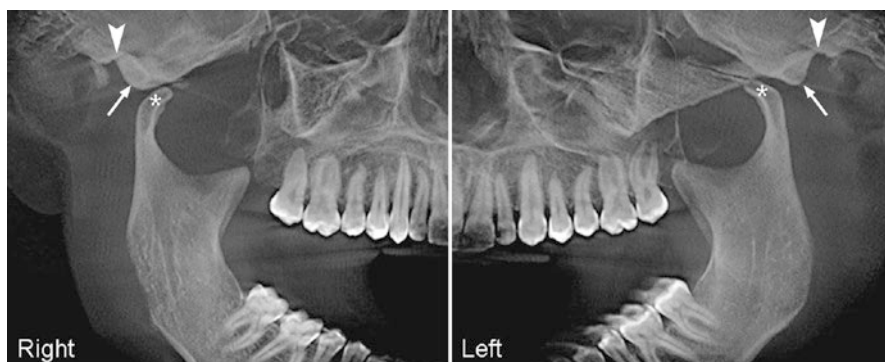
CBCT parasagittal panoramic images of the right and left TMJs showing nontraumatic bilateral dislocations. Both condylar processes (*asterisks*) are dislocated out of their respective glenoid fossae (*arrowheads*). The articular eminences (*arrows*) are within normal limits. Reduction of the condyles may be more challenging with normal or elongated articular eminences
